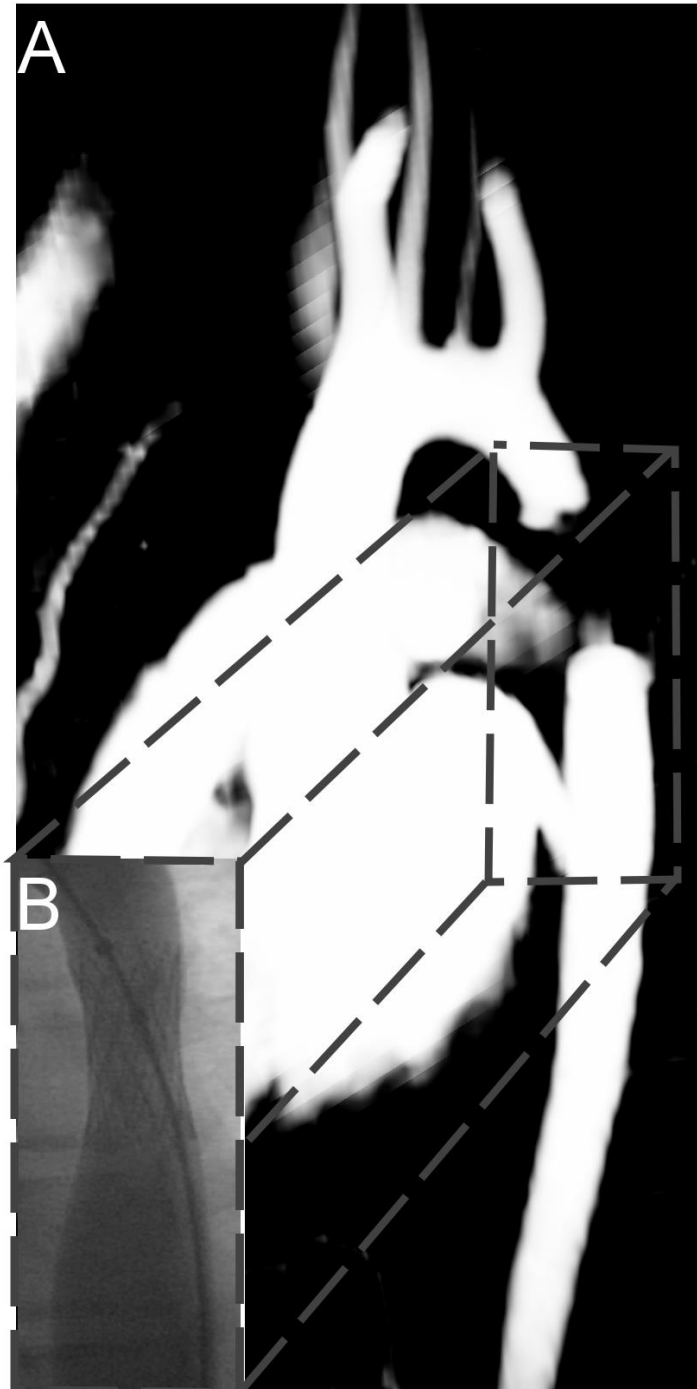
Mean intensity projection of MRI data (A) and an angiographic image of the same patient obtained by fluoroscopy (B). CFD models were constructed using the MRI data with diameters of the stented region extracted from the fluoroscopy data to account for signal dropout created by artifacts due to the implanted Palmaz stent.
